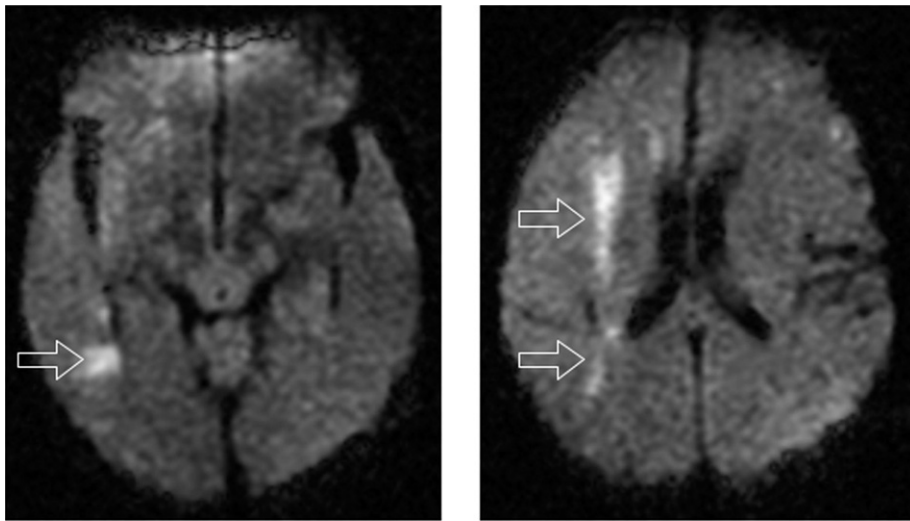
Diffusion-weighted magnetic resonance images of the brain performed 3 days after aortic reconstruction, before carotid stenting. Arrows point to multiple areas of restricted diffusion in the anterior and posterior watershed areas of the right cerebral hemisphere, consistent with acute infarcts.
